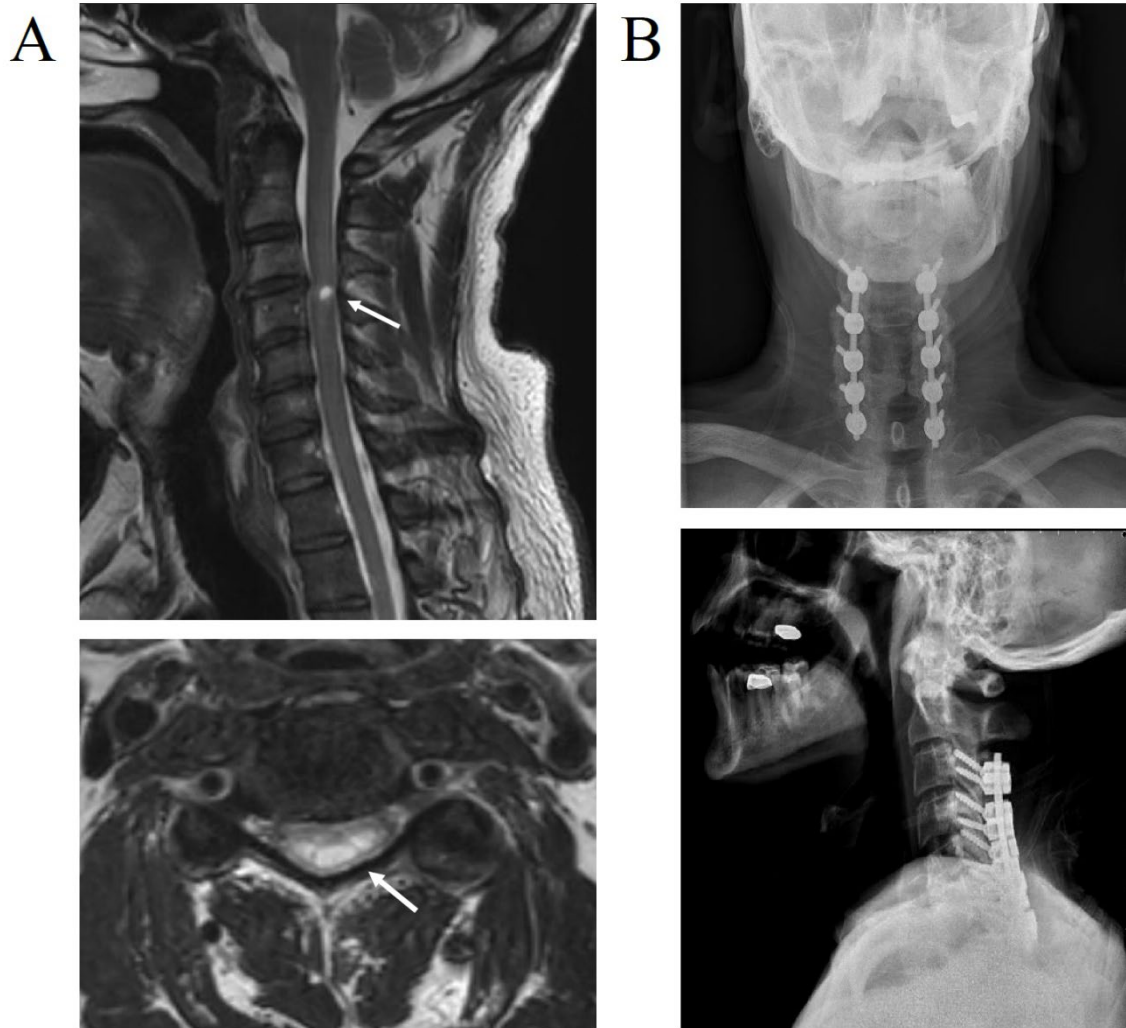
Radiographic images of the injury location and decompression surgery of the cervical spine. (A) T2 weighted sagittal (top) and axial (bottom) magnetic resonance images of the subject's cervical spine at 6 months post-injury. Arrows shows high intensity T2 signal of myelomalacia and atrophy at C3 and C4 spinal level. (B) Anteroposterior (top) and lateral (bottom) x-ray images of cervical vertebra showing laminectomy and arthrodesis surgery
